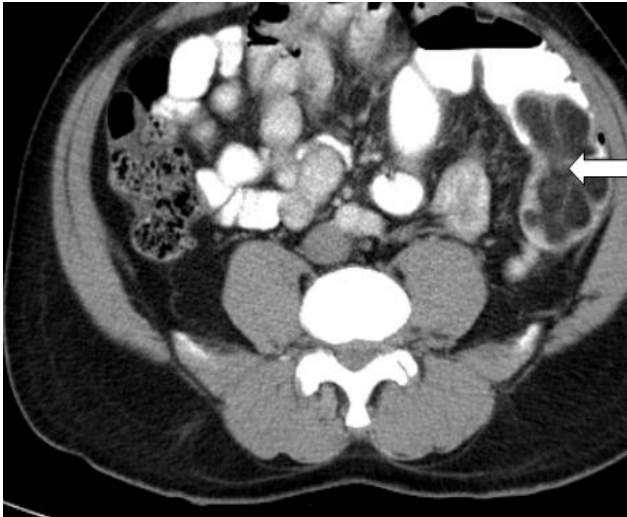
Axial CT image of the abdomen showing left colonic lipoma(Arrow).
